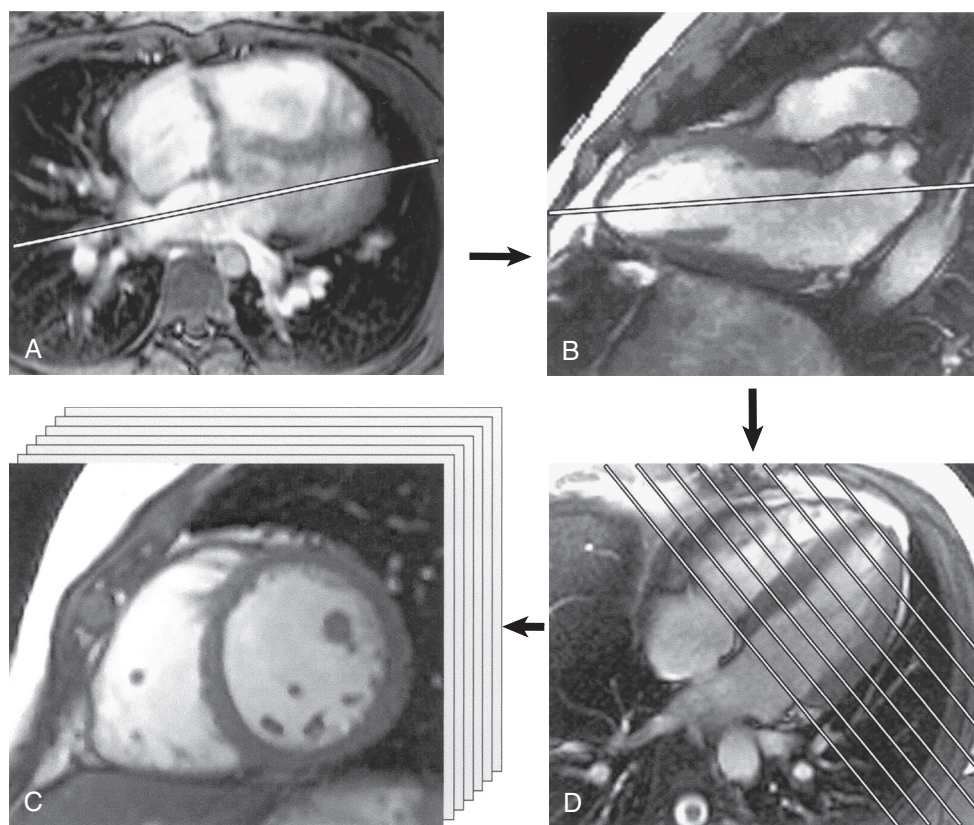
■ Cine magnetic resonance imaging technique for assessment of ventricular dimensions and function. A, Using a localizing image in the axial plane, an imaging plane is placed parallel to the left ventricular septal surface. B, Two-chamber plane. C, Four-chamber plane. D, Short-axis plane. To obtain complete coverage of the ventricles, 12 contiguous imaging slabs are placed from the plane of the atrioventricular valves through the cardiac apex.
